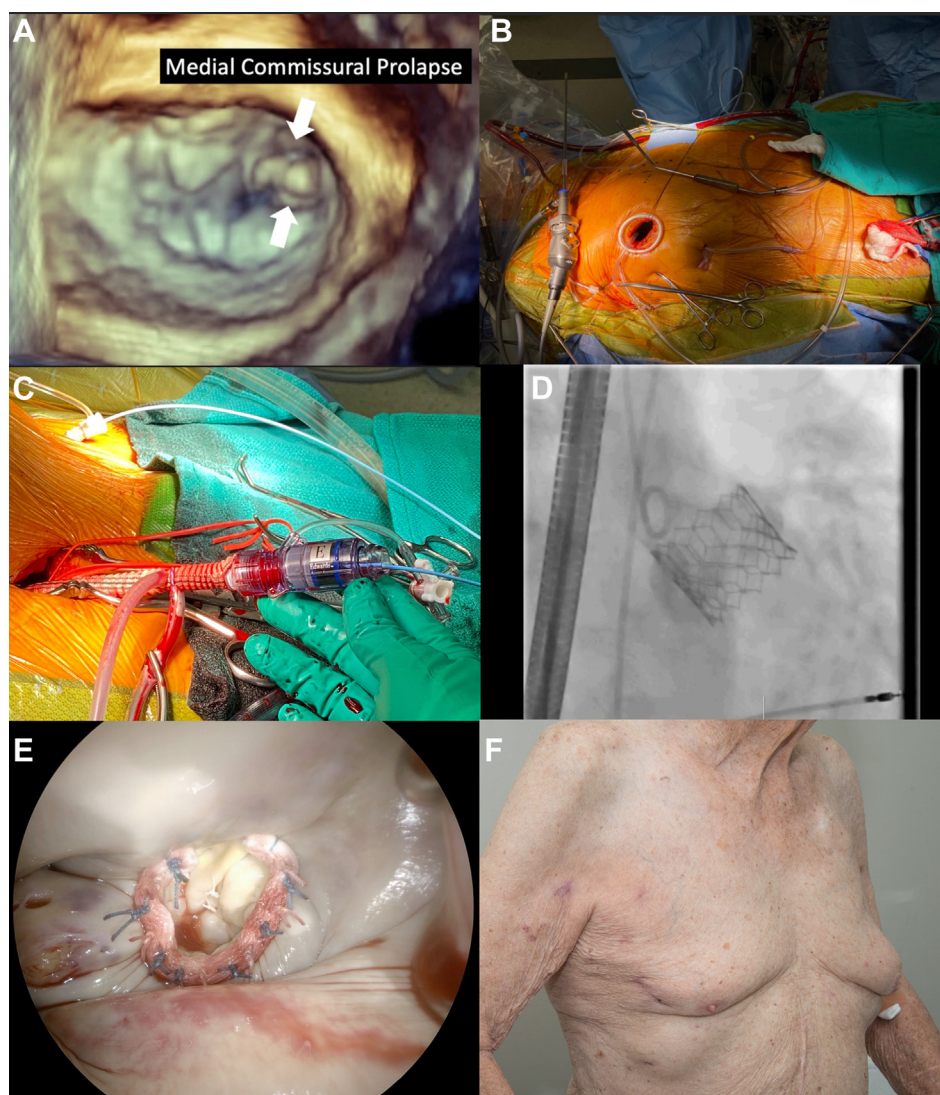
(A) Preoperative transesophageal echocardiogram demonstrated medial commissural prolapse. (B) Patient setup. (C) transcatheter aortic valve replacement valve delivery through an 8-mm right common femoral arterial graft. (D) Final aortogram. (E) Saline test. (F) Postoperative incision.
